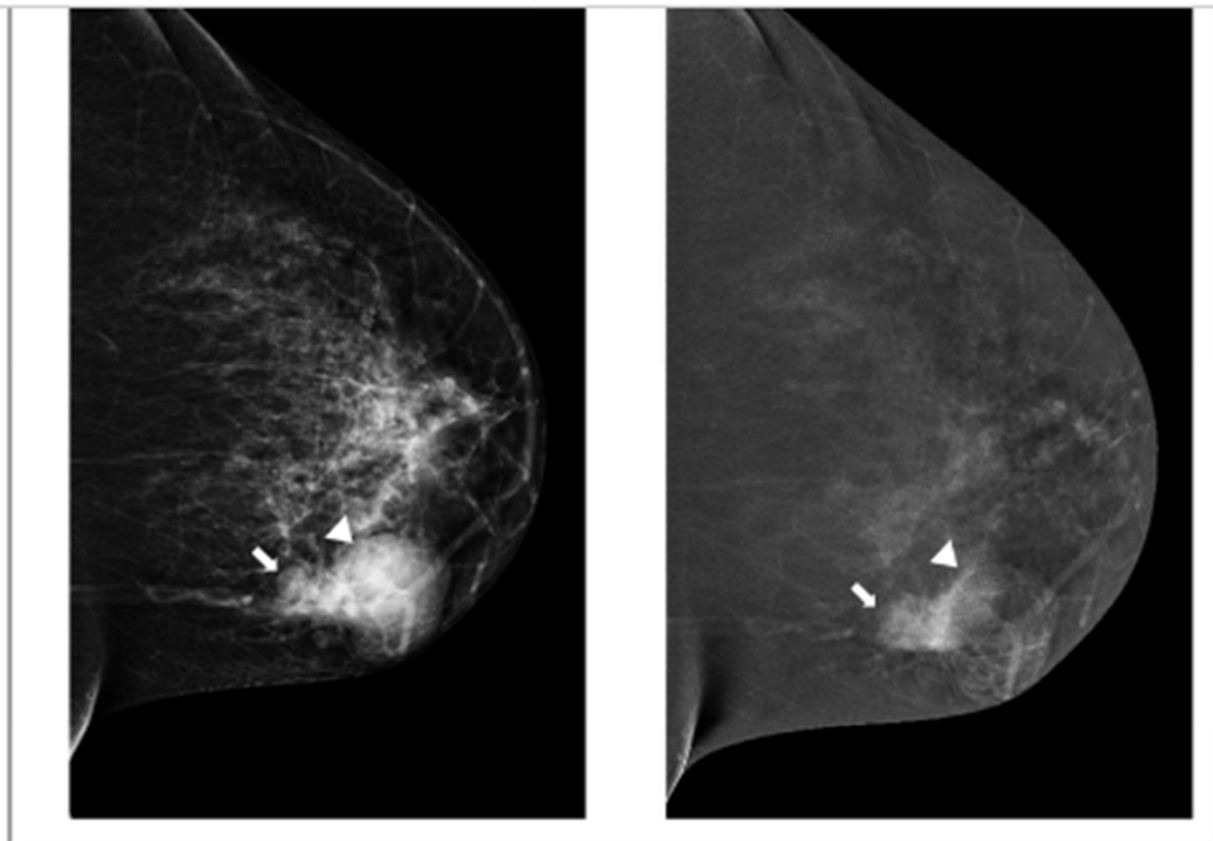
Craniocaudal projections of the right breast in a 46-year-old female who presented for left breast lump. The patient developed an allergic reaction to contrast iodine and therefore images acquisition started only 16 minutes after intravenous contrast venous injection. Lobulated mass confined by well circumscribed margin seen on low-energy image (A). Recombined image (B) still shows marked degree of enhancement within the smaller component of the lesion (B) whereas milder enhancement seen within the larger component (arrow head), likely due to washout. The lesion was biopsied under ultrasound guidance (not shown), proved to be high grade invasive mammary carcinoma.
